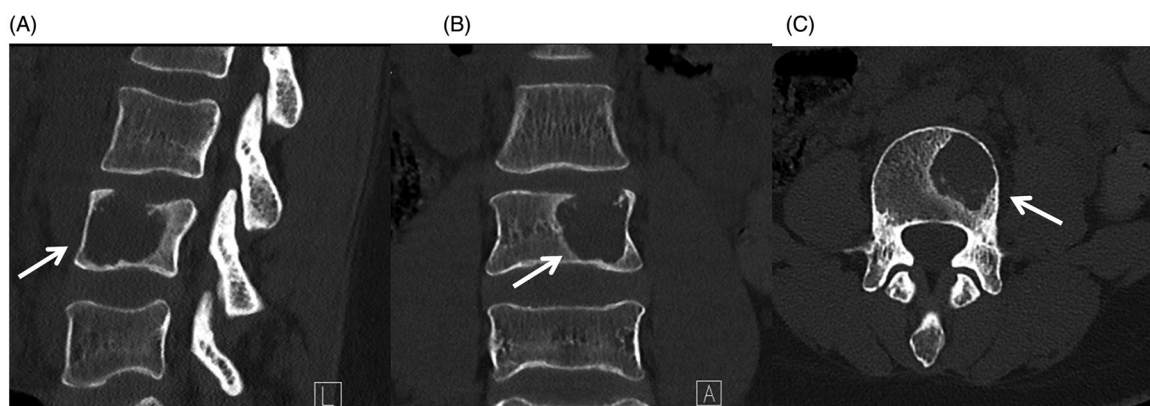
CT lumbar spine at diagnosis. (A) This is a sagittal CT image showing the L4 osteolytic lesion (arrow). (B) This is a coronal CT image showing the lesion (arrow). (C) This is an axial CT image at the level of L4 demonstrating the osteolytic lesion (arrow).
